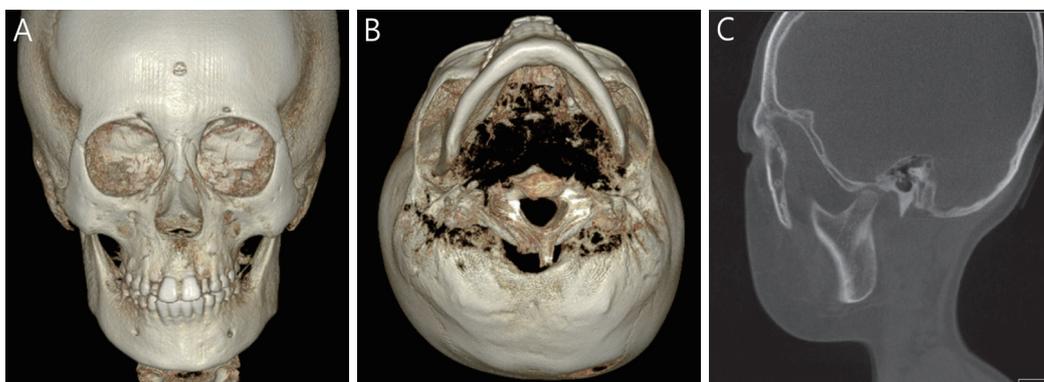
CBCT view after 6 years. (A) Mandibular displacement is decreased in frontal view. (B) Mandibular displacement is within the normal range in axial view. (C) Normal growth has occurred in the left condyle and mandibular ramus.
